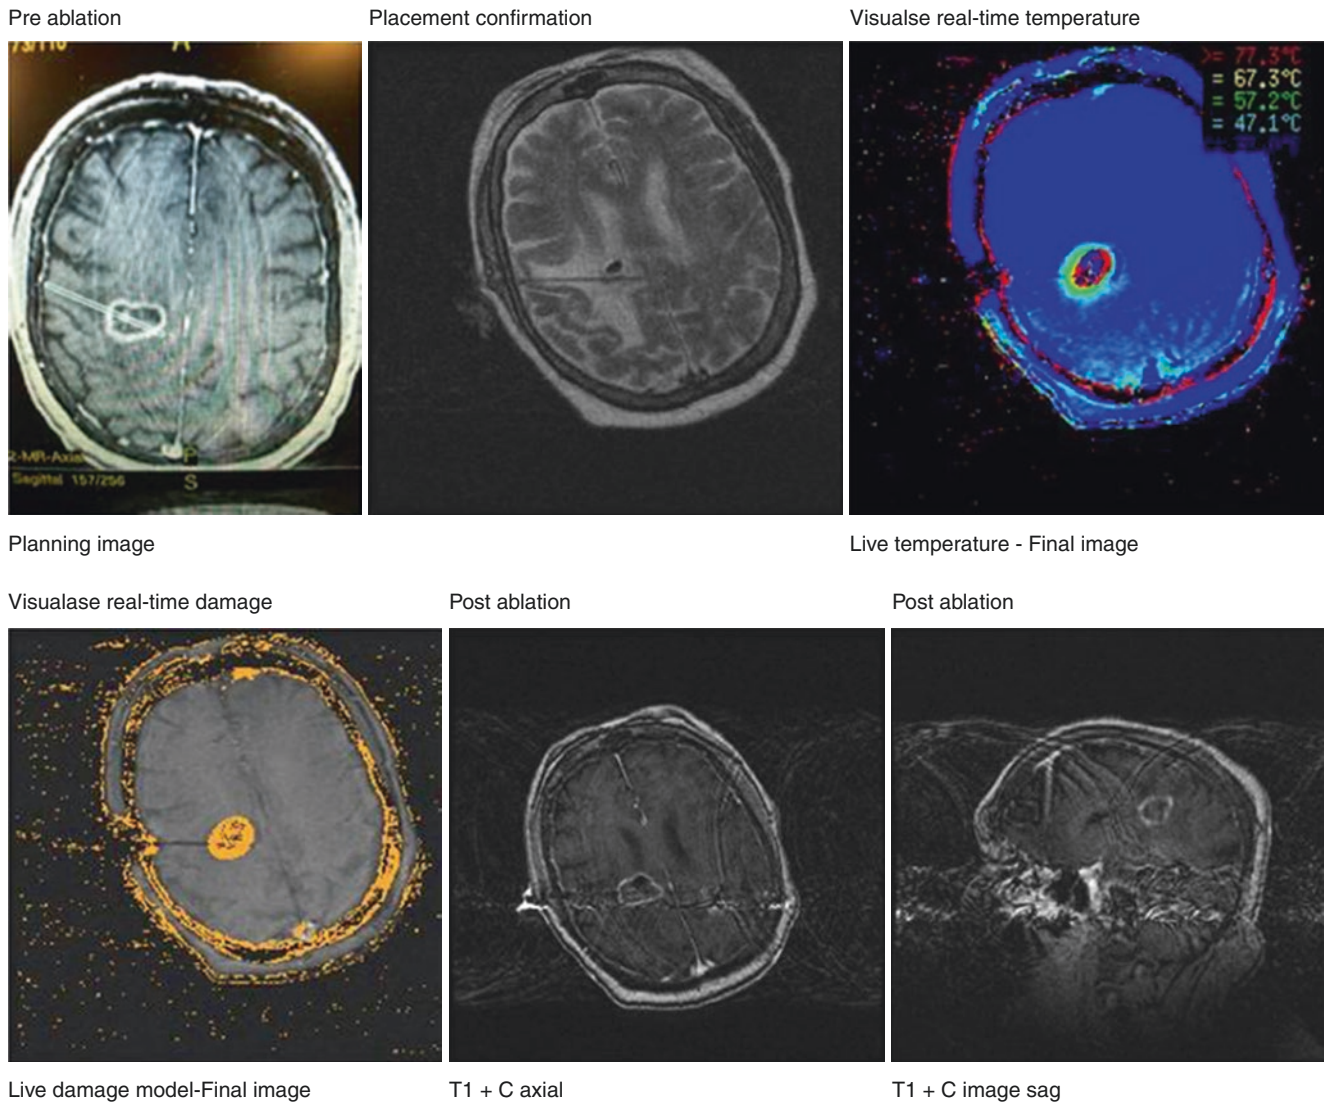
The treatment of a right GBM with the Visualase laser interstitial thermal therapy (LITT) system. MRI was used to confirm catheter placement, followed by real-time monitoring of the temperature and tissue damage zone and final postablative imaging, all done in a single sitting
